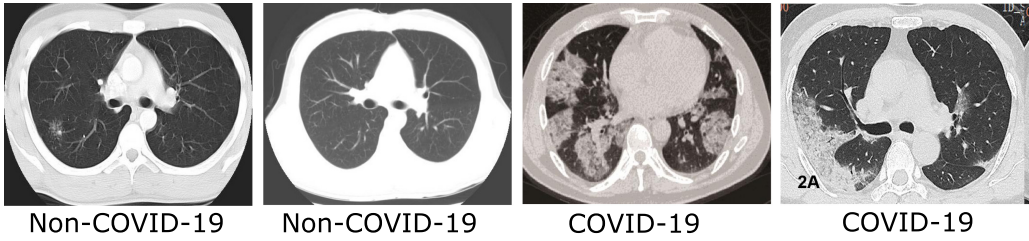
Sample CT scans of COVID-19 and Non-COVID-19 from COVID-19 CT dataset.
